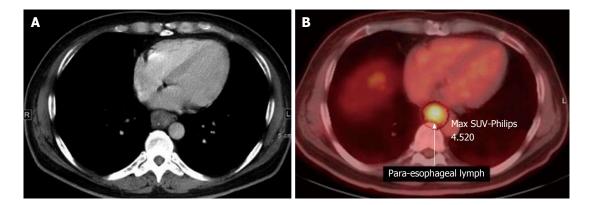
Computed tomography scan showing swelling of a para-esophageal lymph node (A), positron emission tomography-computed tomography did not reveal any other abnormal accumulation (B). The mediastinal mass had 4.520 of the sum of the maximum standard uptake values. SUV: Standardized uptake value.
